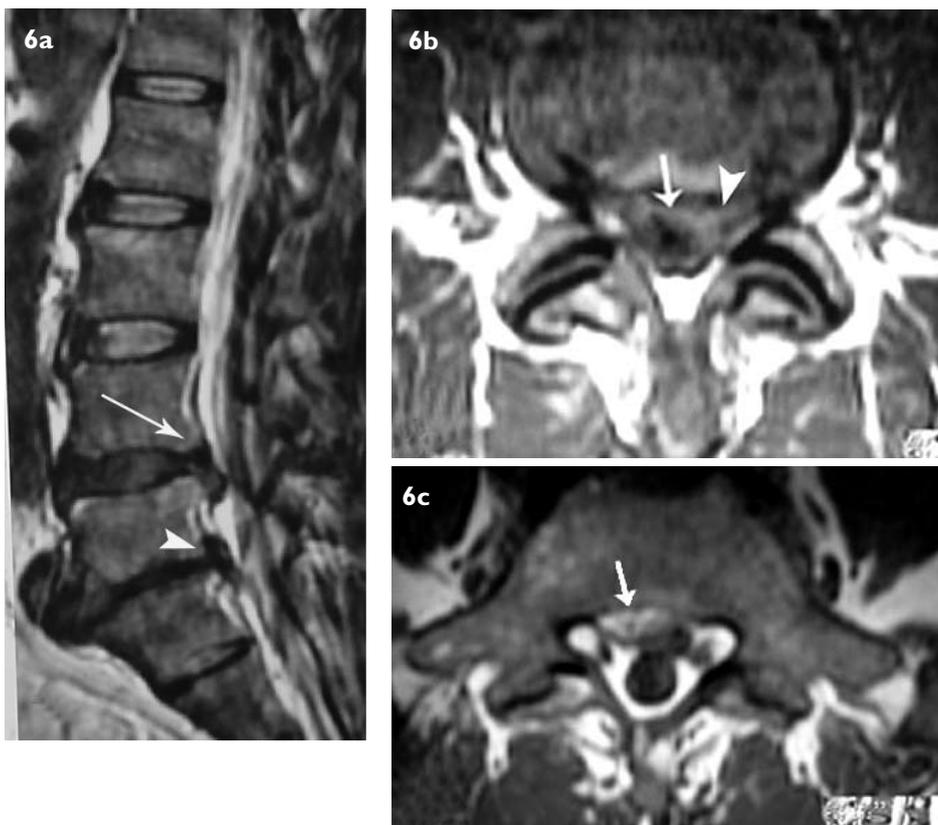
(a) Sagittal T2-W MR image shows two-level disc extrusions at L4-L5 (arrow) and L5-S1 (arrowhead) levels. Caudal subligamentous migration of extruded disc at L4-L5 level is seen. (b) Axial T1-W image taken at L4-L5 level shows disc extrusion associated with mild thecal sac impression (arrow), and severe left lateral recess nerve root compression (arrowhead). (c) Axial T1-W image taken at L5-S1 level shows a disc extrusion (arrow) with mild nerve root compression.
